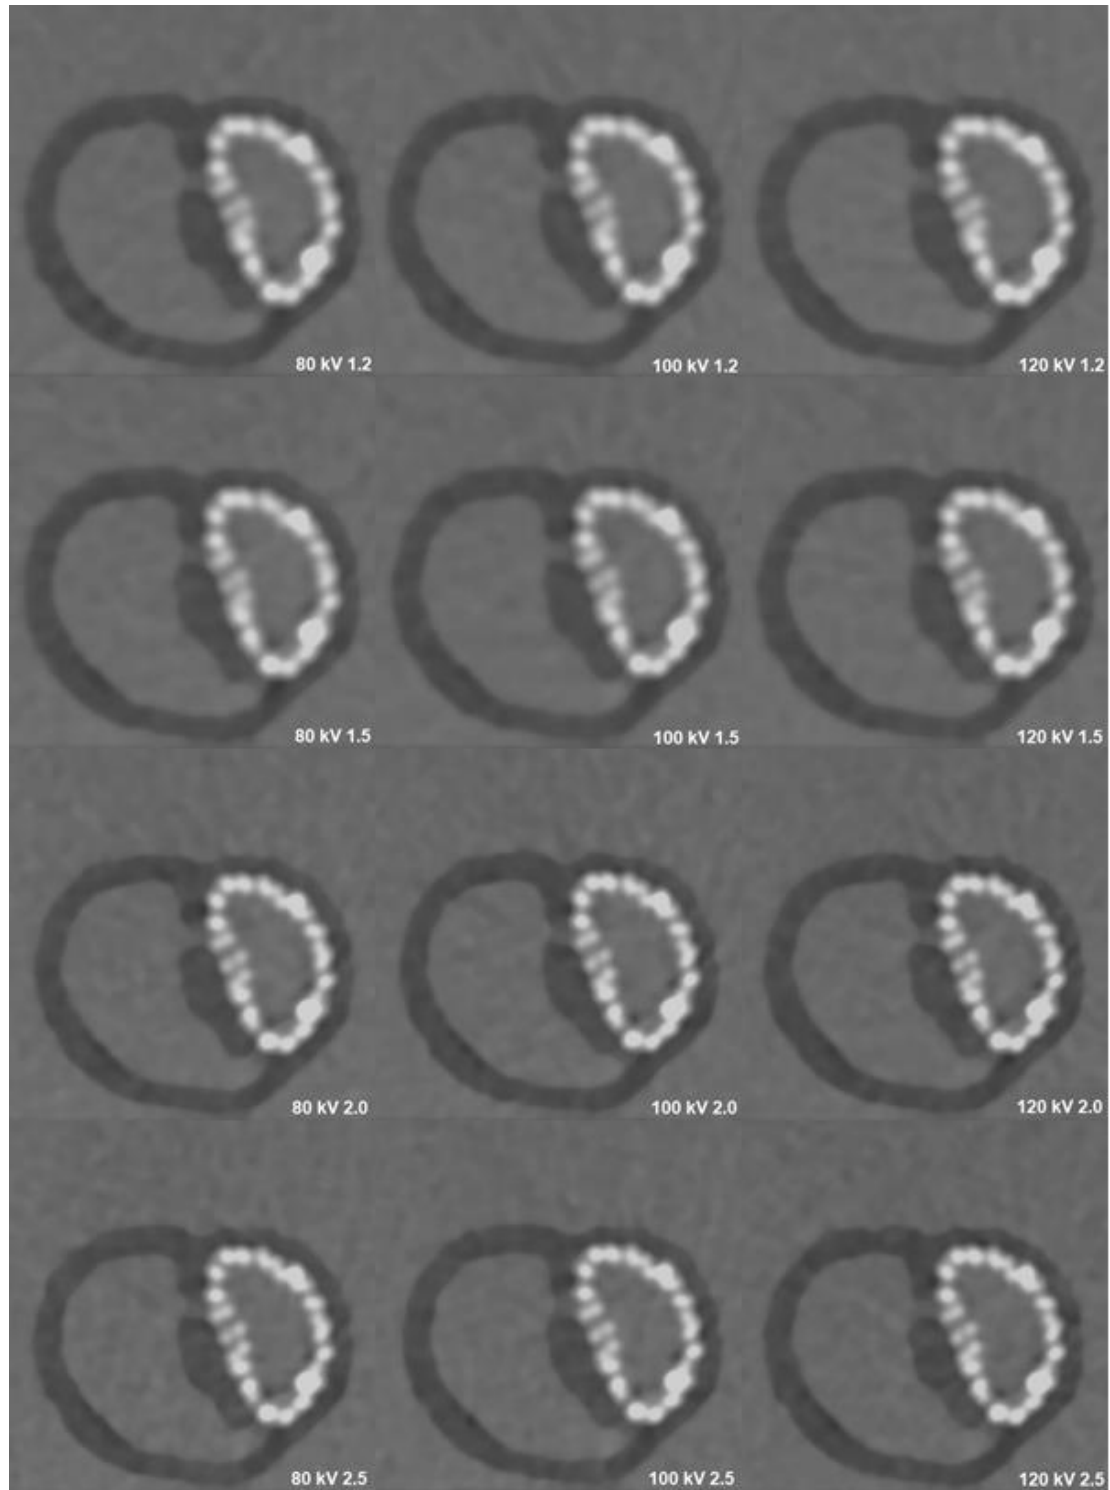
Axial reformatted images of the CTA protocols (80, 100, 120 kVp and pitch value of 1.2, 1.5, 2.0, 2.5). These selected slices include true and false lumen, stent-graft and two of the intimal flap tears.
